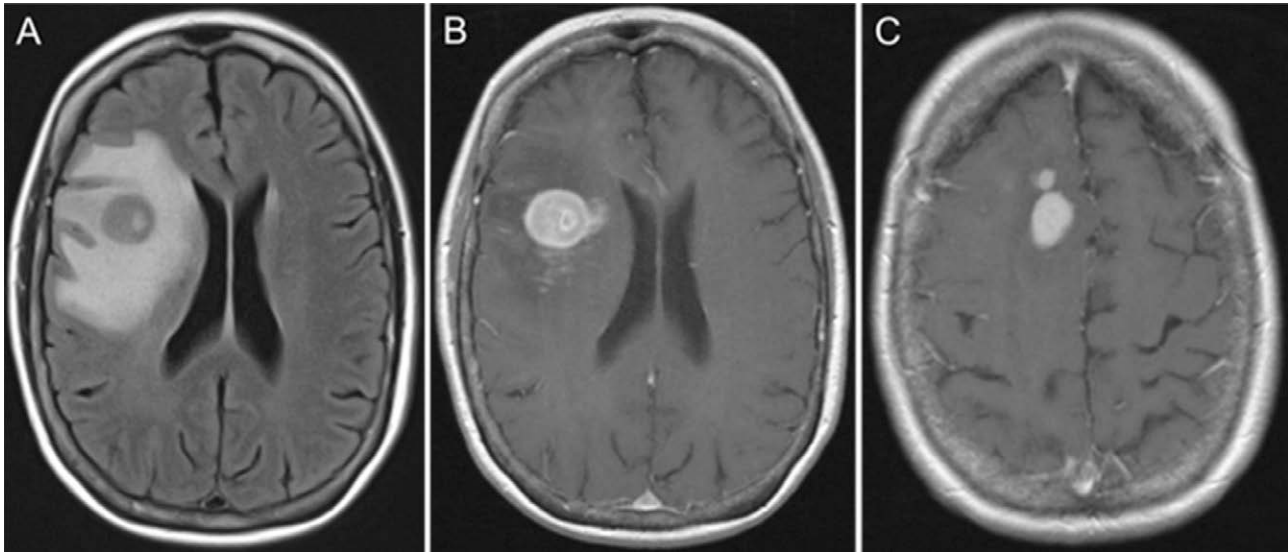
The mass lesions are hypointense on fluid attenuated inversion recovery (FLAIR) images (A) and homogeneously enhancing on T1-weighted images after administration of gadolinium (B and C). Surrounding vasogenic edema is hyperintense on FLAIR and hypointense on T1.
